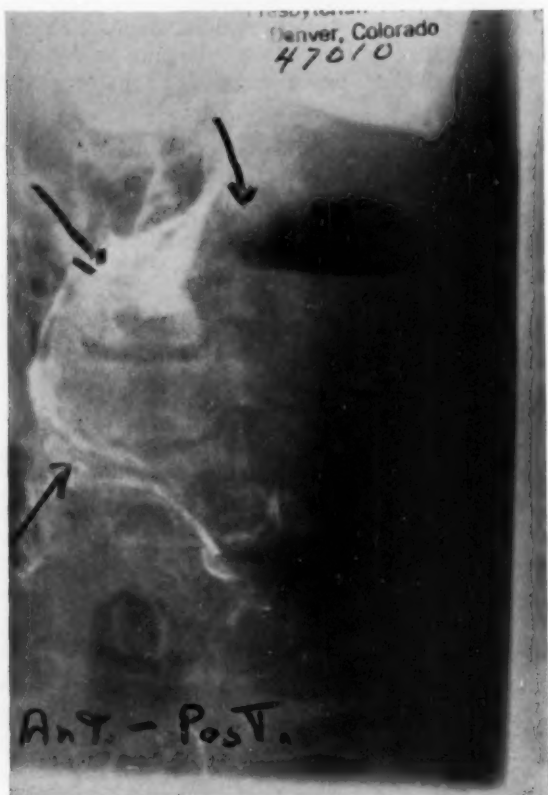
X-ray Examination: 7 cm. diameter soft tissue mass with air-fluid level left cervical area above level of vocal cords, causing moderate posterior and right lateral pressure defect and deviation on hypopharynx. Incidental finding—Degenerative narrowing 4th, 5th, and 6th cervical interspaces with osteoarthritic lipping at these narrowed interspaces posteriorly.
